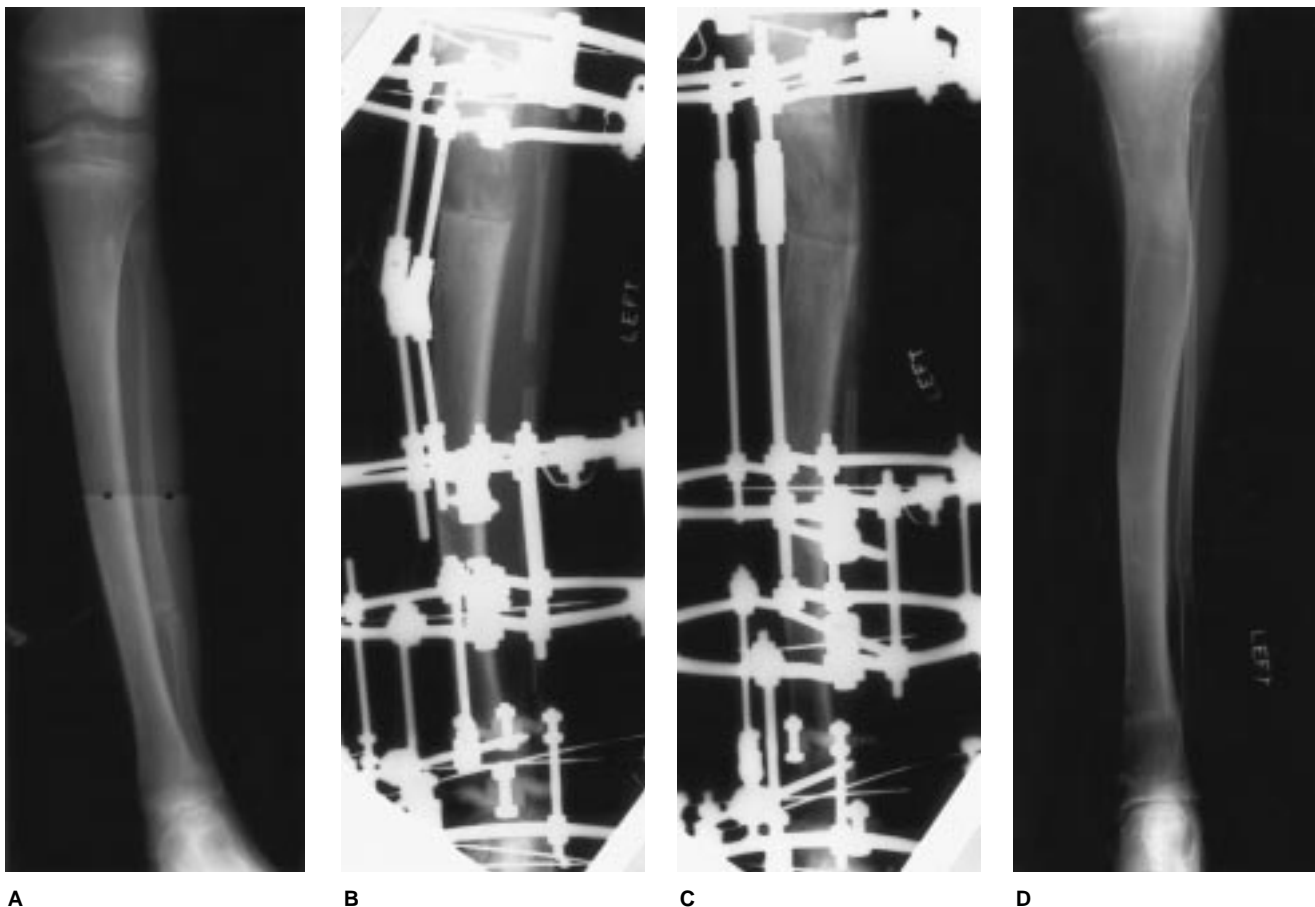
Radiographs of a child with a 6-cm limb-length discrepancy due to fibular hemimelia. A, Anteroposterior radiograph depicts proximal and distal tibial valgus, as well as ball-and-socket ankle and hypoplasia of the fibula. Patient previously underwent tibial lengthening with a monolateral fixator. B, Acute correction of distal tibial valgus deformity was performed. Frame was constructed to first lengthen the proximal tibia and then achieve angular correction. Note hinge application at apex of proximal tibial valgus deformity distal to site of corticotomy. Frame extends to foot to prevent subluxation or contracture. C, Radiographic appearance after desired lengthening. Progressive correction of proximal tibial valgus was then sequentially performed, with desired bending of regenerate. D, End result, with equalization of limb length and mechanical-axis realignment.
